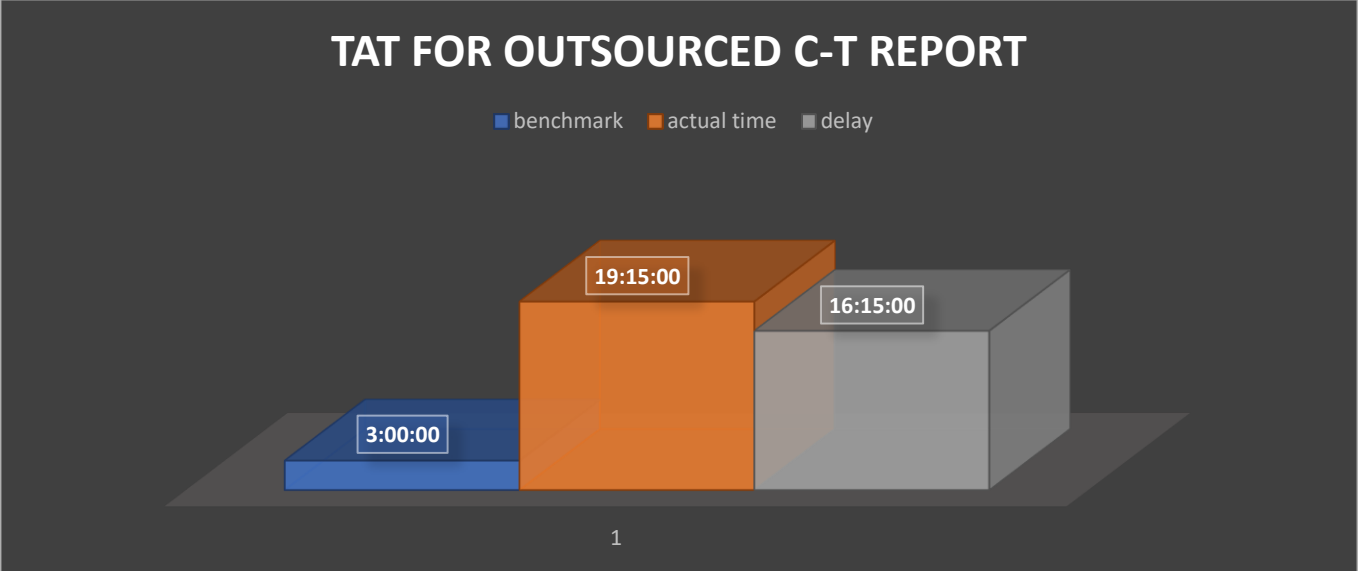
Represents the Turnaround time for CT reports (Outsourced) for the month of March
